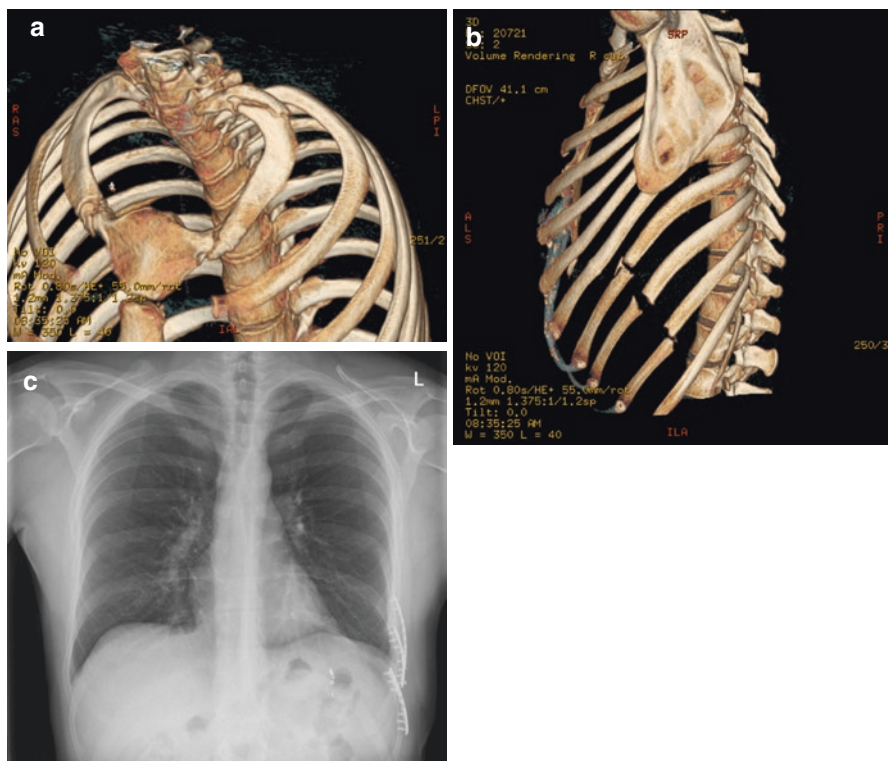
A 34-year-old male, injured in a high-velocity road traffic collision. (a) Three-dimensional CT scan reconstructions of the ribs 4 months after the injury, showing non-union of a left first rib fracture. (b) A series of painful, atrophic, non-united fractures of the left eighth, ninth and tenth ribs. The seventh rib fracture has united. (c) Chest radiograph 6 weeks after surgical stabilisation of the eighth, ninth and tenth non-united rib fractures, with debridement of the rib ends, iliac crest bone grafting and locking plates and screws. Note the splenic artery embolisation coil and that one screw has loosened
